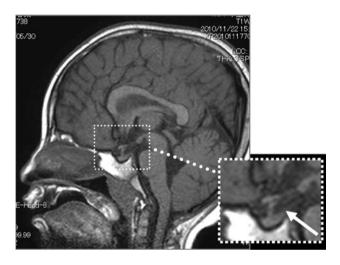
The sagittal section of T1-weighted brain MRI. A *rectangle* area bounded by *dotted lines* is enlarged to show the details of the pituitary gland and its surrounding region. The arrow indicates the absence of a high intensity signal of the posterior lobe in pituitary gland
